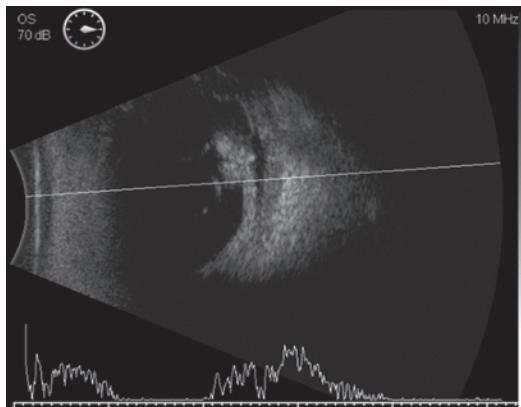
Vitreous opacity, suspected retinal and choroidal detachment, thickening of the ocular wall on B-ultrasound
